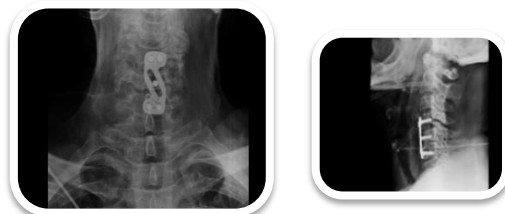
Immediate post-operative X-ray showing anterior C4-C5 fusion
